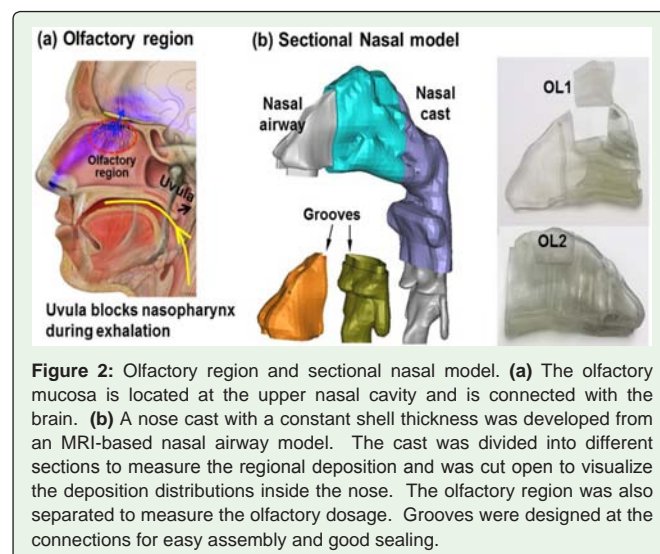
Olfactory region and sectional nasal model. (a) The olfactory mucosa is located at the upper nasal cavity and is connected with the brain. (b) A nose cast with a constant shell thickness was developed from an MRI-based nasal airway model. The cast was divided into different sections to measure the regional deposition and was cut open to visualize the deposition distributions inside the nose. The olfactory region was also separated to measure the olfactory dosage. Grooves were designed at the connections for easy assembly and good sealing.
